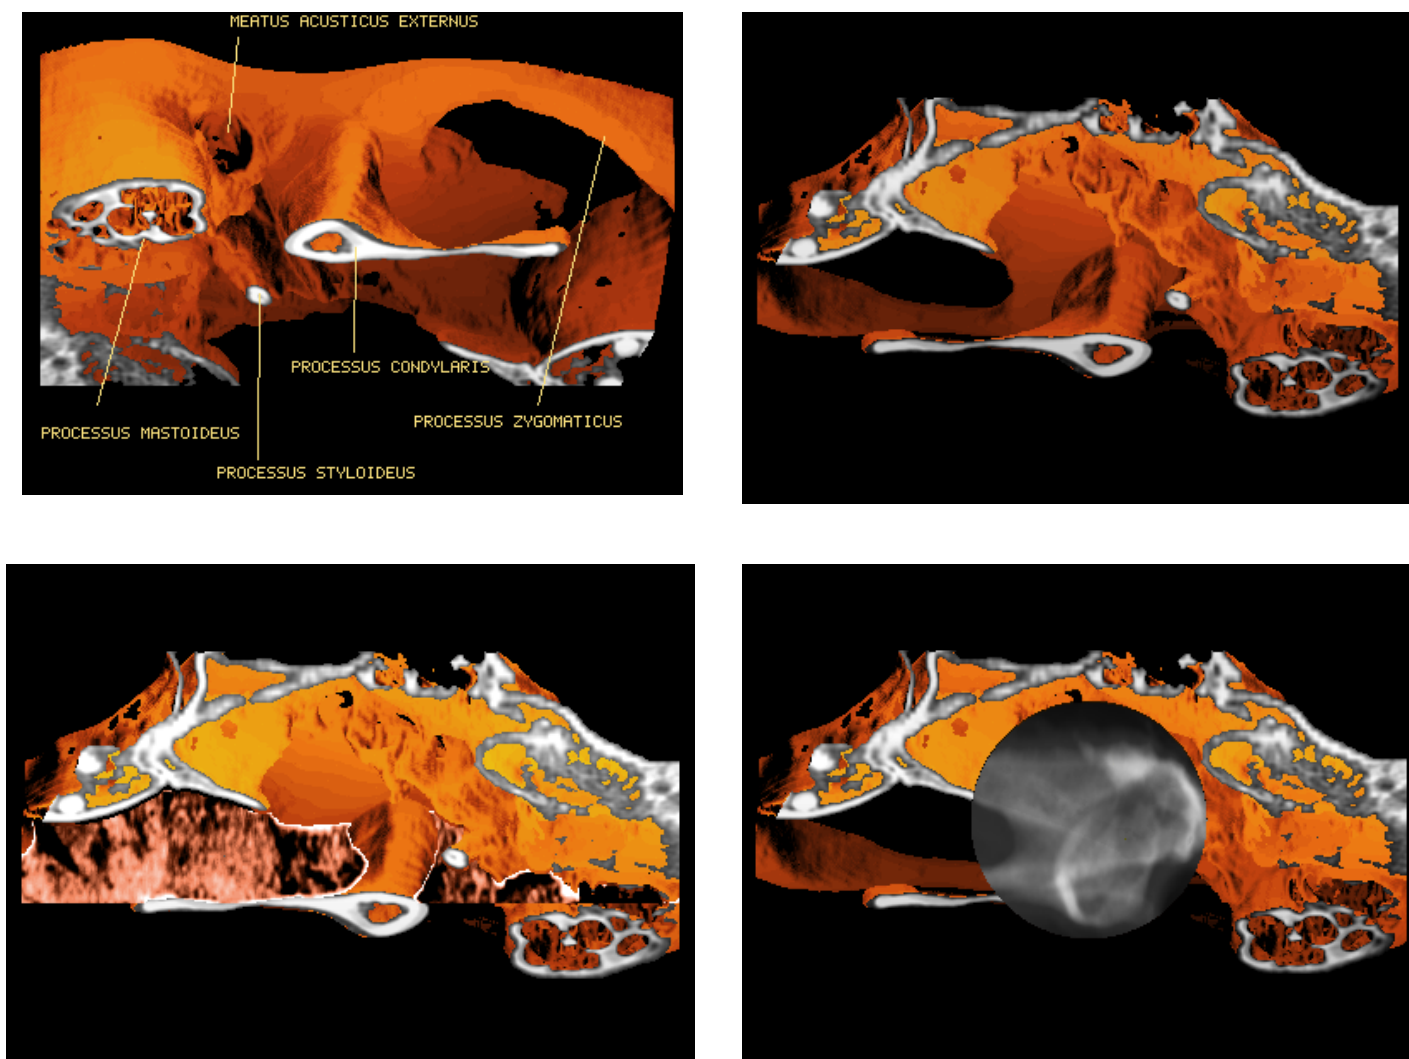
Surface display of a portion around the TMJ produced from the 20 CT slices of patient 2.
